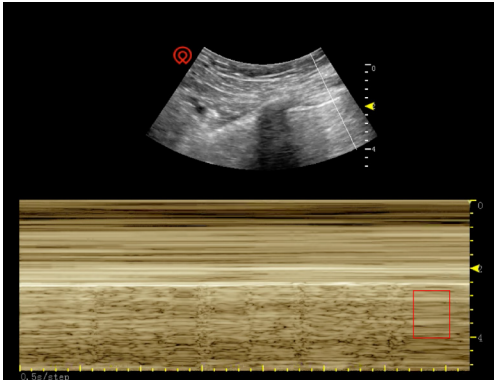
Ultrasound showed an advection level sign on M-mode during the operation. Red square indicates the advection level sign on M-mode, whereas no B line could be detected on ultrasonography.
